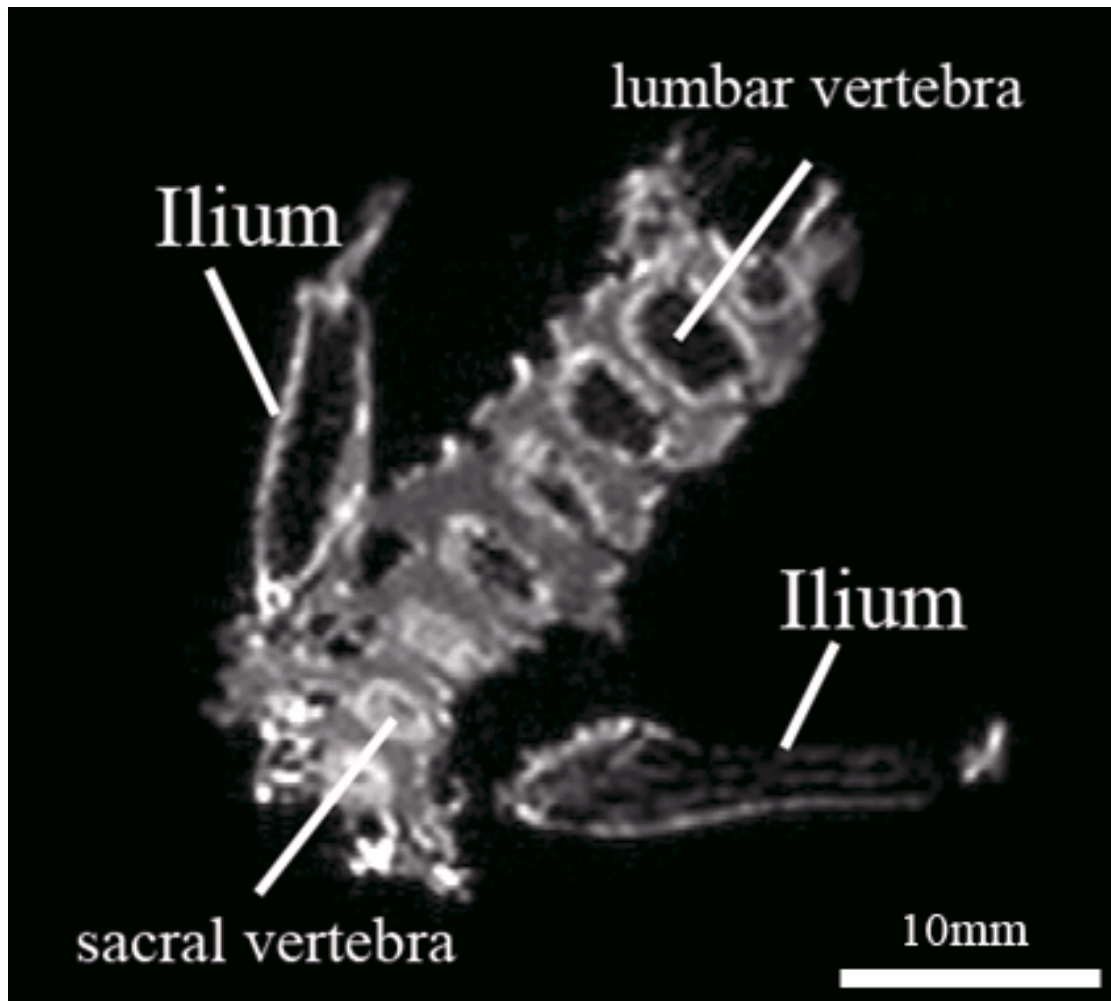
2D coronal μ MRI slice through fetal pelvis displaying right and left iliac blades as well as lumbar and sacral vertebrae. Note the poor definition of trabeculae within the ilium and vertebral bodies.
